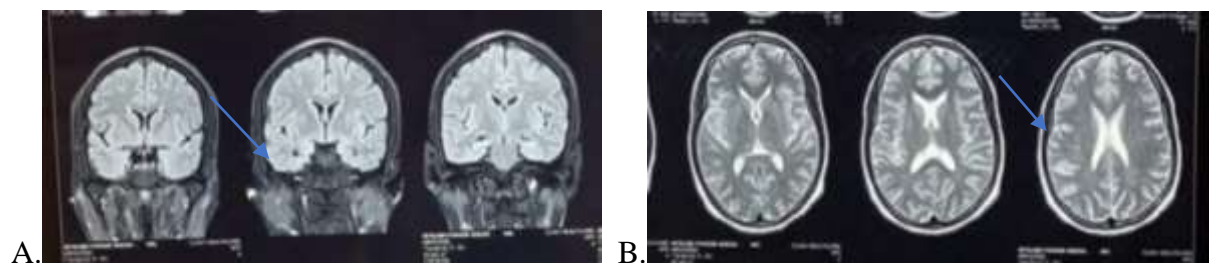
a-b: Magnetic resonance images (MRI) of the brain show (A) normal mesial temporal lobe (arrow) in the fluid attenuated inversion recovery (FLAIR) corona image, and (B) white matter hypo-intensities (arrow) in the T2-weighted sequence.
